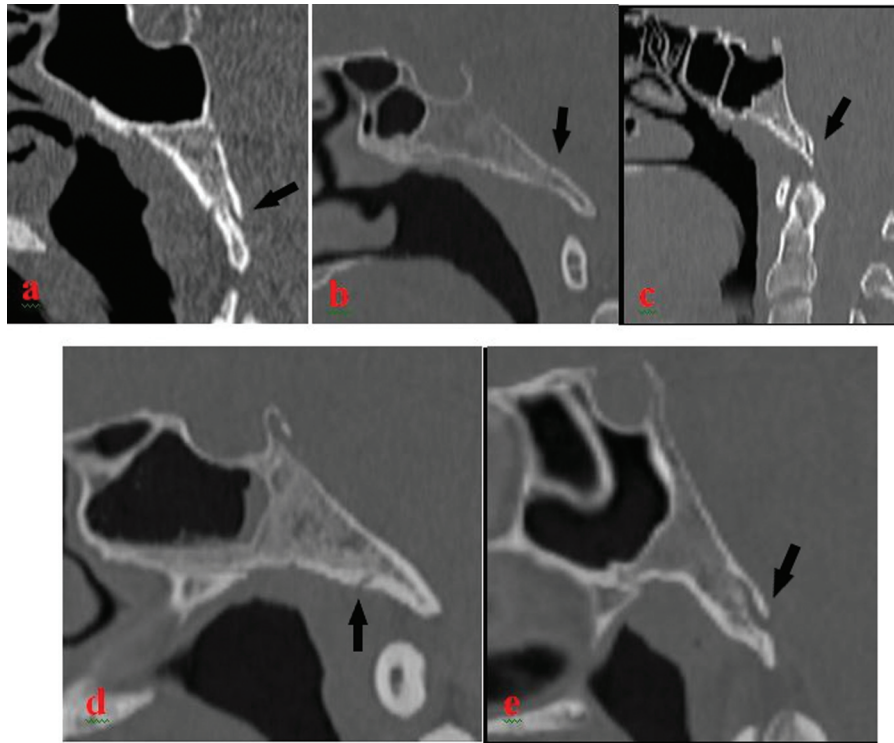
Computed tomography (CT) images of canalis basilaris medianus (CBM) types in the study. (a) Type 1. (b) Type 2. (c) Type 3. (d) Type 4. (e) Type 6. Type 5 could not be observed in these study data.
